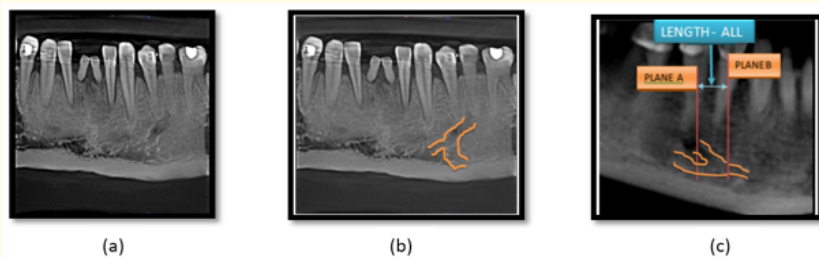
a. Presence or absence of anterior loop was identified on panoramic reconstruction done on CBCT dicom images. As seen in the image; b. Panoramic reconstruction in CBCT, showing anterior loop and incisive branch; c. CBCT image showing the plane A and B, as well as length of anterior loop
